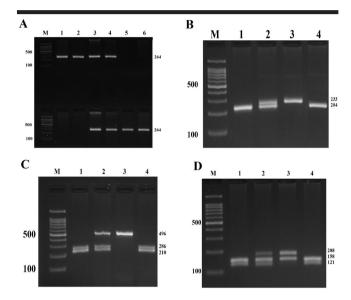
a-d. The electrophoresis pattern of IFN-γ (+874T/A), IFN-γR1 (-611A/G), (+189T/G), and (+95C/T) polymorphisms. (a) The electrophoresis pattern of ARMS-PCR on 2% agarose gel at +874 T/A SNP; M marker 100 bp, 1 and 2 genotype AA, 3 and 4 genotype AT, 5 and 6 genotype TT. (b) The digestion pattern of Hpy188I restriction enzyme on 3% agarose gel at -611 A/G SNP; M marker 100 bp, 1 and 4 genotype GG, 2 genotype AG, 3 genotype AA. (c) The digestion pattern of Taql restriction enzyme on 2% agarose gel at +189T/G SNP, M marker 100 bp, 1 and 4 genotype GT, 3 genotype TT. (d) The digestion pattern of BstC8I restriction enzyme on 3% agarose gel at +95 C/T SNP; M marker 100 bp, 1 and 4 genotype CC, 2 genotype CT.
